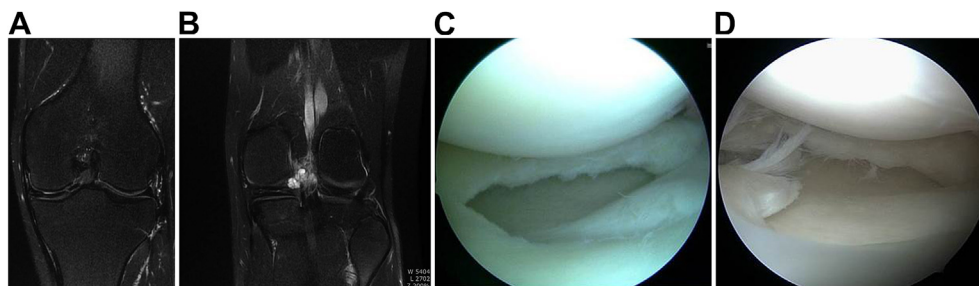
MRI and arthroscopic images of an 18-year-old male (patient 1) who presented with left knee pain and locking. (a) Coronal T2-weighted image showing meniscus tear with degeneration of the white–white zone. (b) Coronal T2-weighted image showing horizontal tear with cyst formation in the posterior horn of the medial meniscus. (c) The complex torn meniscus was partially resected. (d) Arthroscopic image obtained 4 years after partial meniscectomy showing a re-tear of the remaining medial meniscus extending from the body to the posterior horn.
